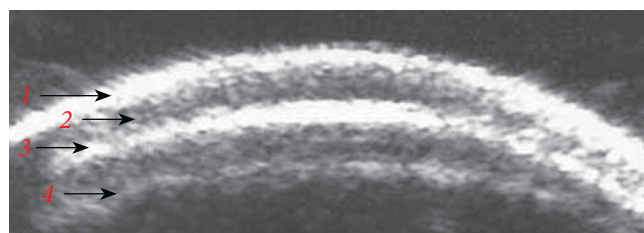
Scalp and skull ultrasonography under normal conditions: 1 — skin, 2 — subcutaneous tissue, 3 — bone, and 4 — reverberation artifacts
